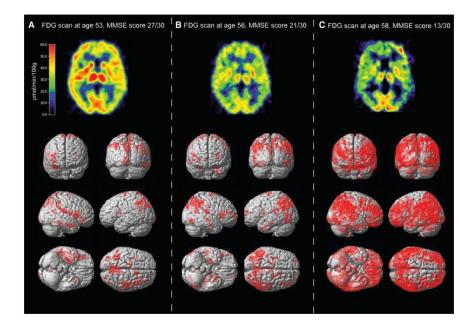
18F-FDG scans of the brain. Colors represent the rate of radiotracer uptake at 53-years-old (a), 56-years-old (b), and 58-years-old (c). Reprinted from "Positron Emission Tomography Imaging and Clinical Progression in Relation to Molecular Pathology in the First Pittsburgh Compound B Positron Emission Tomography Patient with Alzheimer's Disease," by A. Kadir et al. 2011, *Brain*, *134*(1), para 34. Copyright 2010 by the Oxford University Press.
